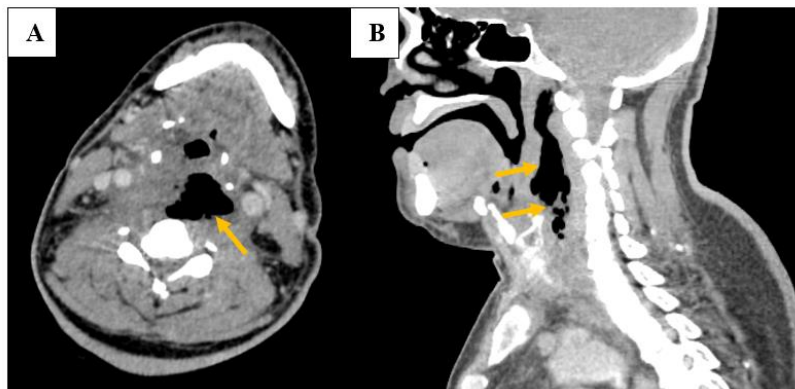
Initial contrast-enhanced axial (A) and sagittal (B) CT scan of the neck demonstrating a quite well limited retropharyngeal abscess containing air bubbles (yellow arrows)
